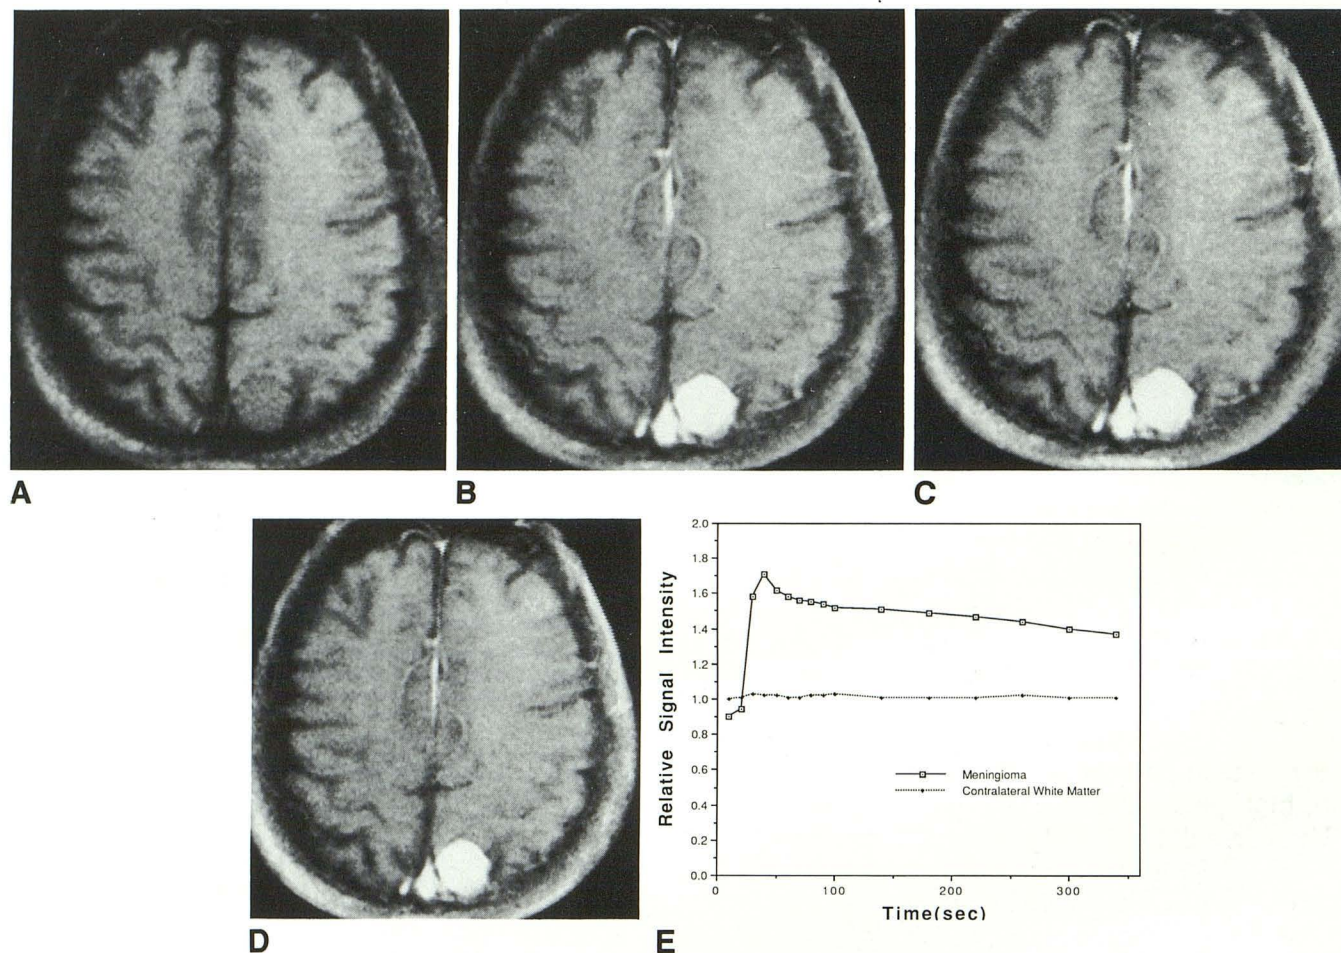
Dynamic MR images (A–D) and time-intensity curve (E) of left parasagittal meningioma. The short TE FLASH sequence was employed: TR/TE/flip angle/NSA = 45/4/45/1,  $192 \times 256$  matrix, and section thickness = 8 mm. Before (A) and 20 (B), 80 (C), 320 (D) sec after administration of Gd-DTPA. The tumor was enhanced entirely with maximum signal intensity at the early phase (B), followed by gradual signal decrease in the later images (C and D). The time-intensity curve of the tumor corresponded to type 2, ie, steep increase and subsequent gradual decrease pattern.
